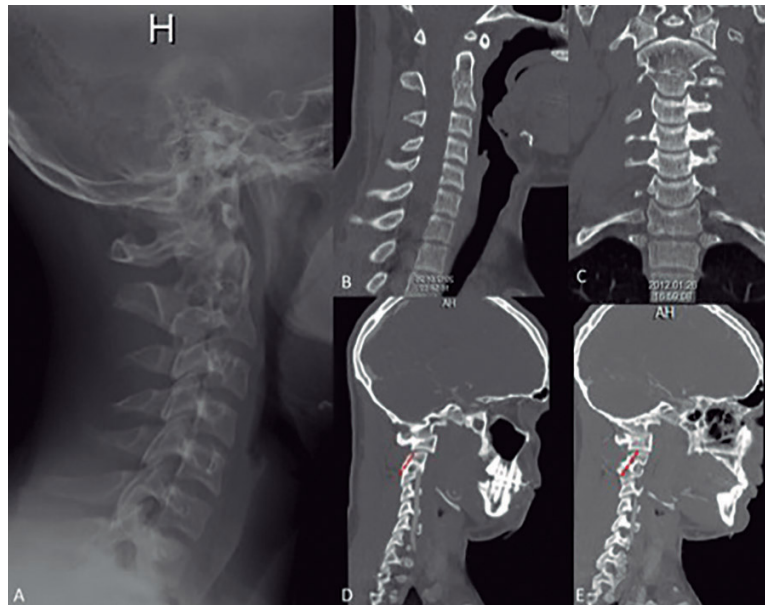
Preoperative imaging studies; os odontoideum + C2-3 congenital fusion + C1-2 instability. A: lateral radiograph; B: sagittal CT; C: coronal CT; D: parasagittal CT with C2 right side pars screw path highlighted for the right side; E: parasagittal CT with C2 left side pars screw highlighted.
